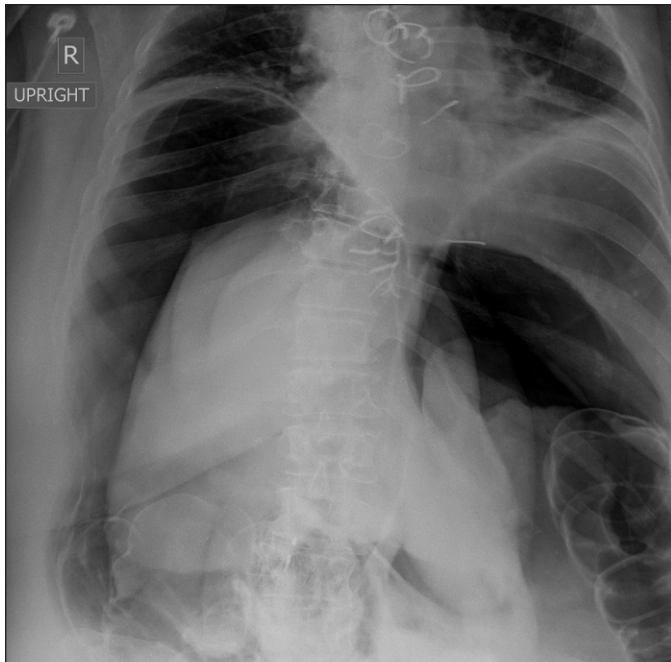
Abdominal x-ray demonstrating the pneumoperitoneum.
